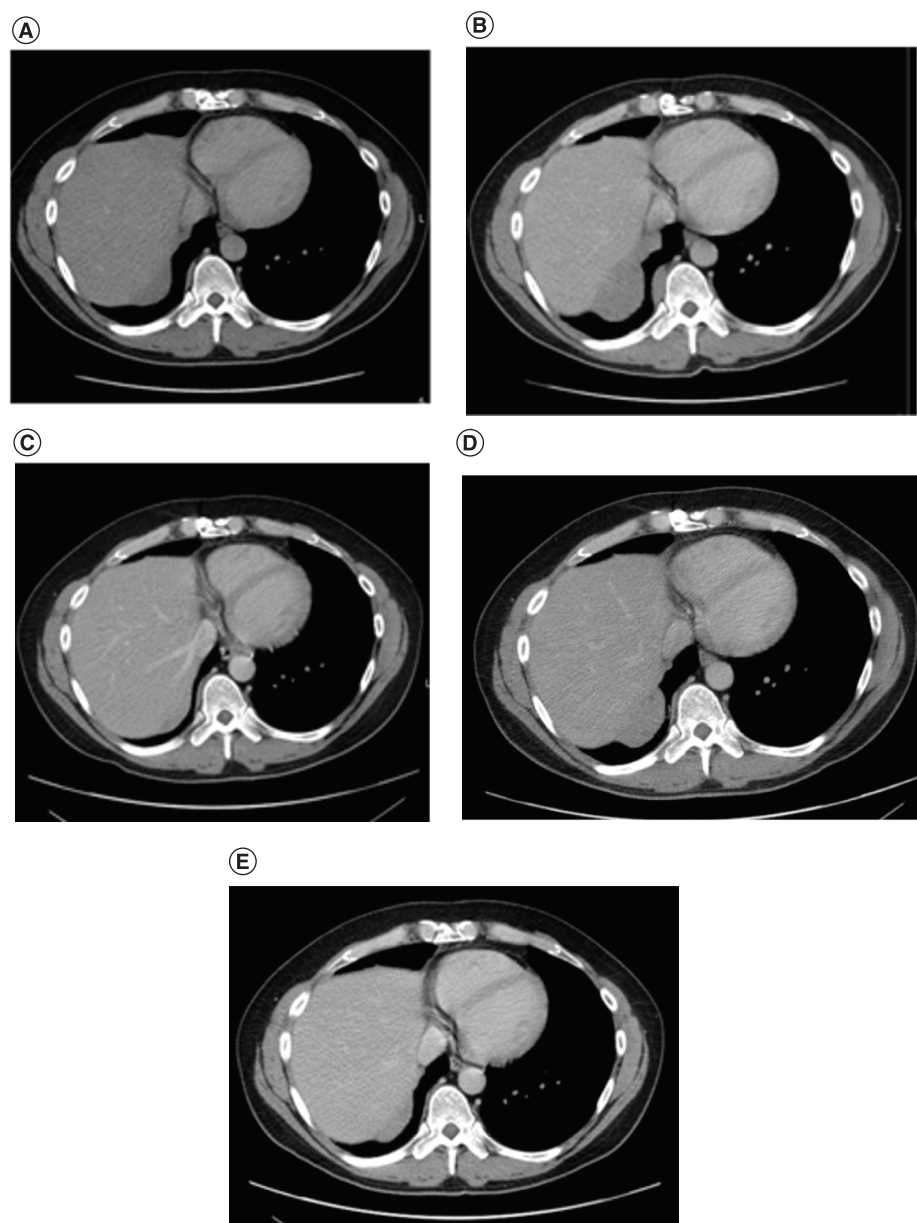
Computed tomography scan showing partial response in a patient with thymoma. (A) Eight months before study. (B) Study baseline. (C) Best response on combination therapy (7 months on study) and start of monotherapy. (D) Progressive disease while on monotherapy (14 months on study) and restart of combination therapy. (E) End of combination therapy and resumption of monotherapy (18.5 months on study).
